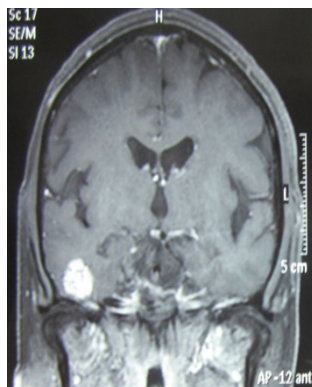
MRI showing tumor located in the middle cranial fossa and based on anterior surface of petrous part of temporal bone with homogeneous enhancement on administration of contrast
